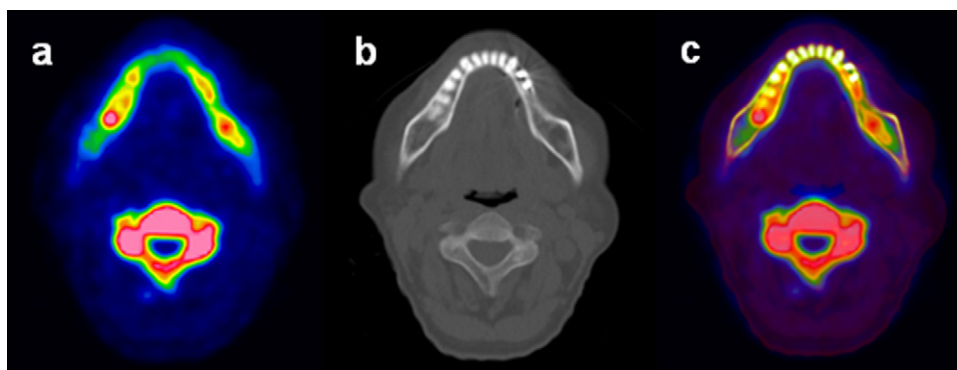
Transverse images: (a) PET image; (b) CT image; (c) fusion image.
